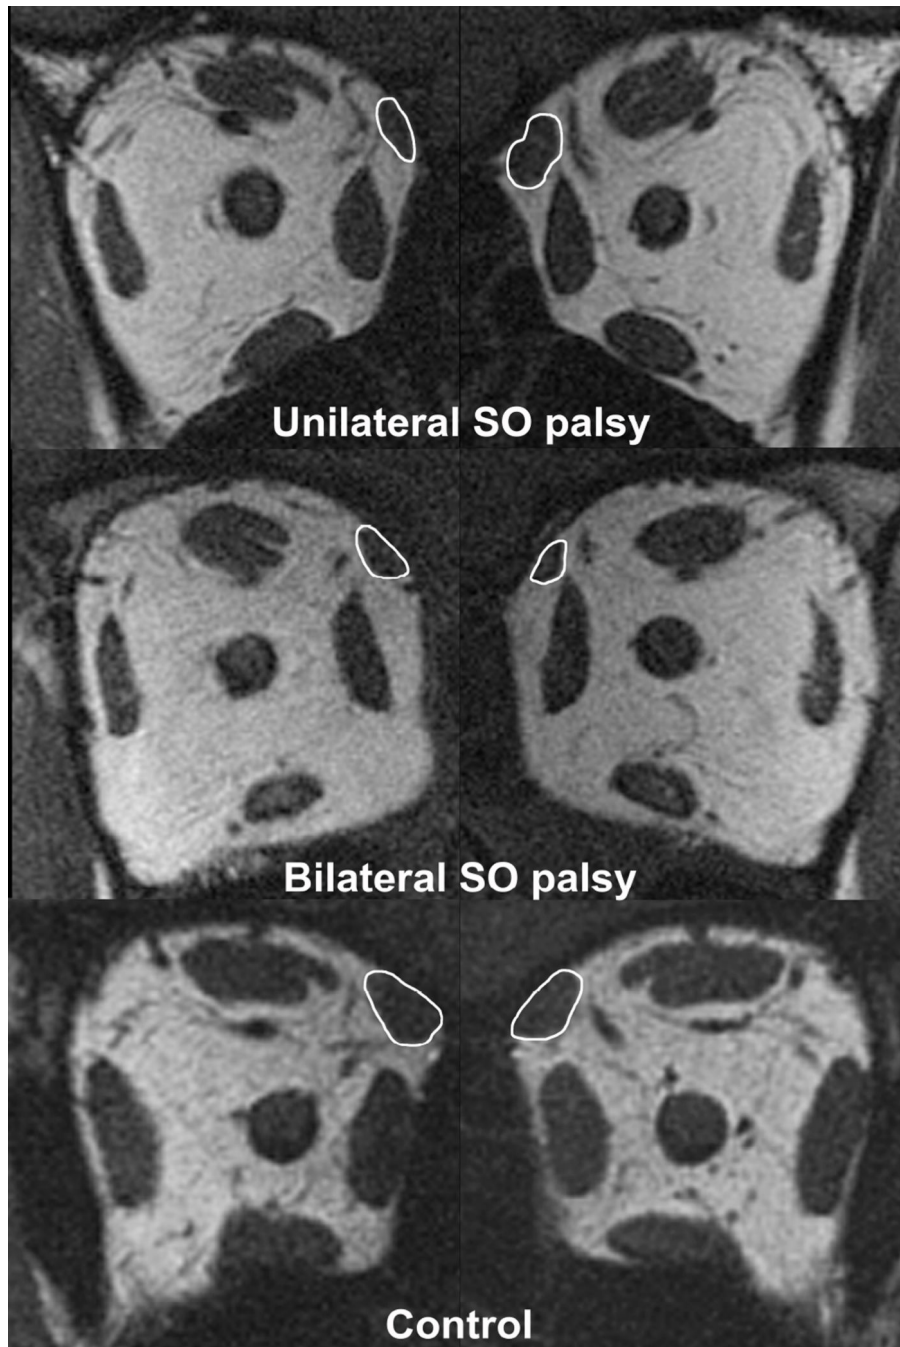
Quasicoronal MRI of right (left column) and left (right column) orbits in patients with superior oblique (SO) palsy and a normal control. Note the smaller size of the right SO muscle compared with left SO muscle in unilateral SO palsy (top row). Both SO muscles are small in bilateral SO palsy (middle row).
